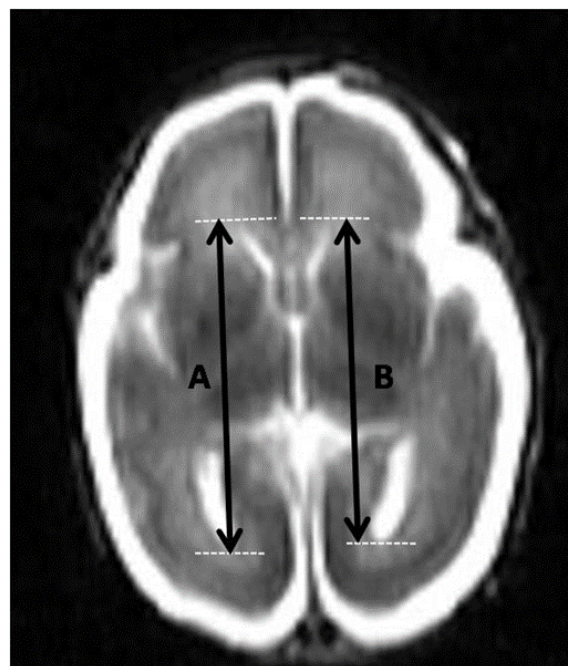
27 weeks of gestation age. transverse cranial MR image of a male fetus. A. right lateral ventricle depth. B. Left lateral ventricle depth.
